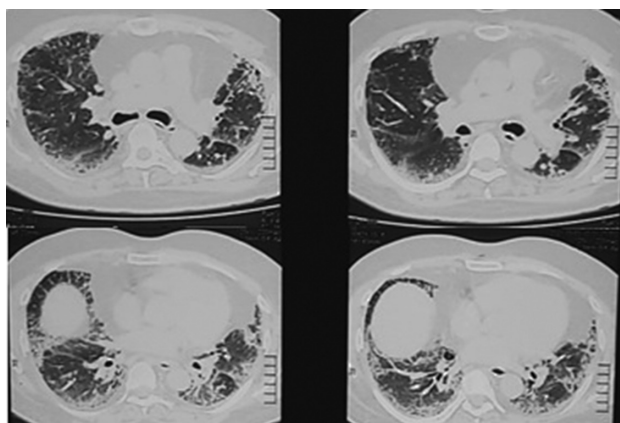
CT scan thorax showing bilateral diffuse reticulations and early honeycomb change in a patient with long-COVID. CT, computed tomography.
